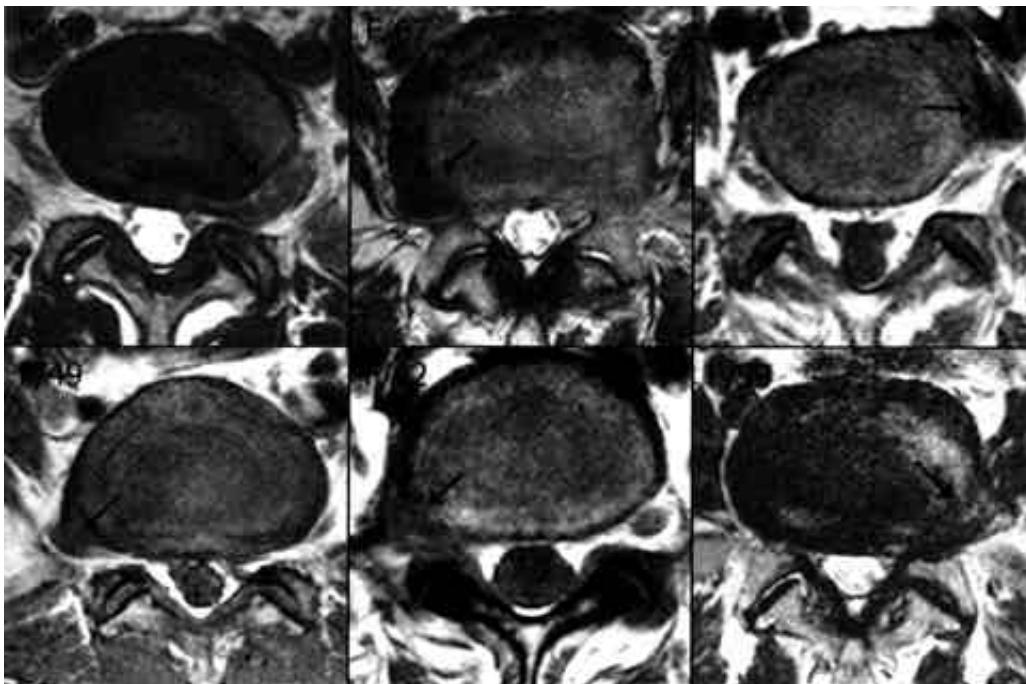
MR images of foraminal disc herniation. These three cases could not be confirmed with sagittal images alone, but together with axial images.
